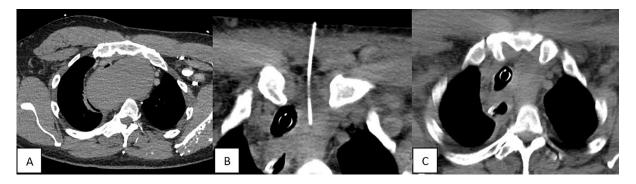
Axial pre-procedural CT Chest showing large cystic middle mediastinal mass with compression of surrounding mediastinal vasculature (A), intra-procedural CT showing percutaneous aspiration of the cystic mediastinal mass with an 18-guage catheter (B), and post-procedural CT showing near-complete decompression of the cystic mass, with improving tracheal deviation (C).
